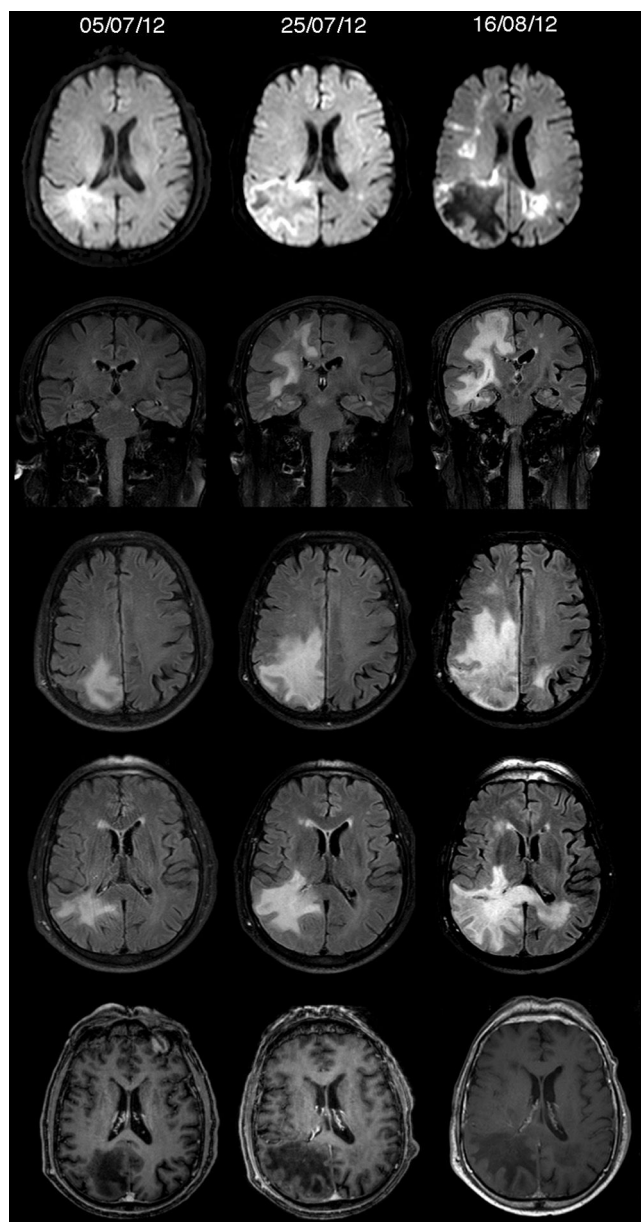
Diffusion-weighted sequences, coronal and axial FLAIR sequences, and gadolinium-enhanced T1-weighted sequences. Timeline of our patient's MR images. The lesion was initially located in the right parieto-occipital area; it was hyperintense on T2/FLAIR sequences, it displayed no contrast uptake or mass effect, and was bright on diffusion-weighted images. In about a month, the lesion progressed from focal to multifocal, affecting the corpus callosum and cortex.
